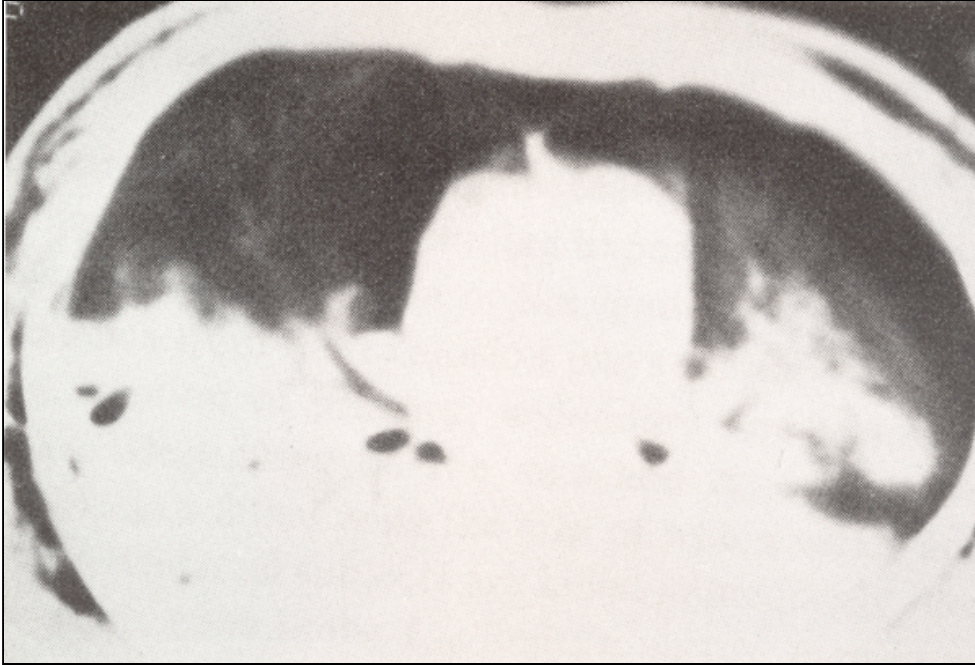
This CAT scan of a blast casualty's thorax shows extensive subcutaneous emphysema that may obscure intrathoracic findings in a more routine roentgenographic evaluation.
